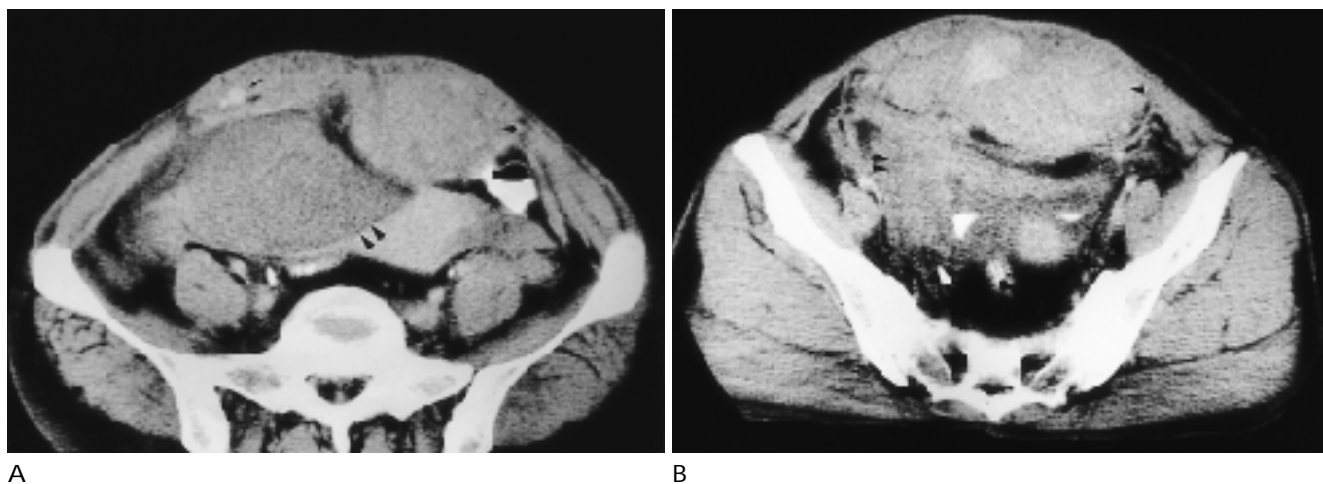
Contrast enhanced pelvic CT.
